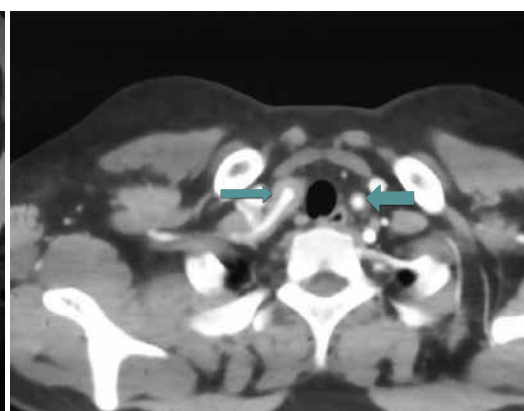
CT angiogram of chest blood vessels – mural thickening seen in both the subclavian arteries.
